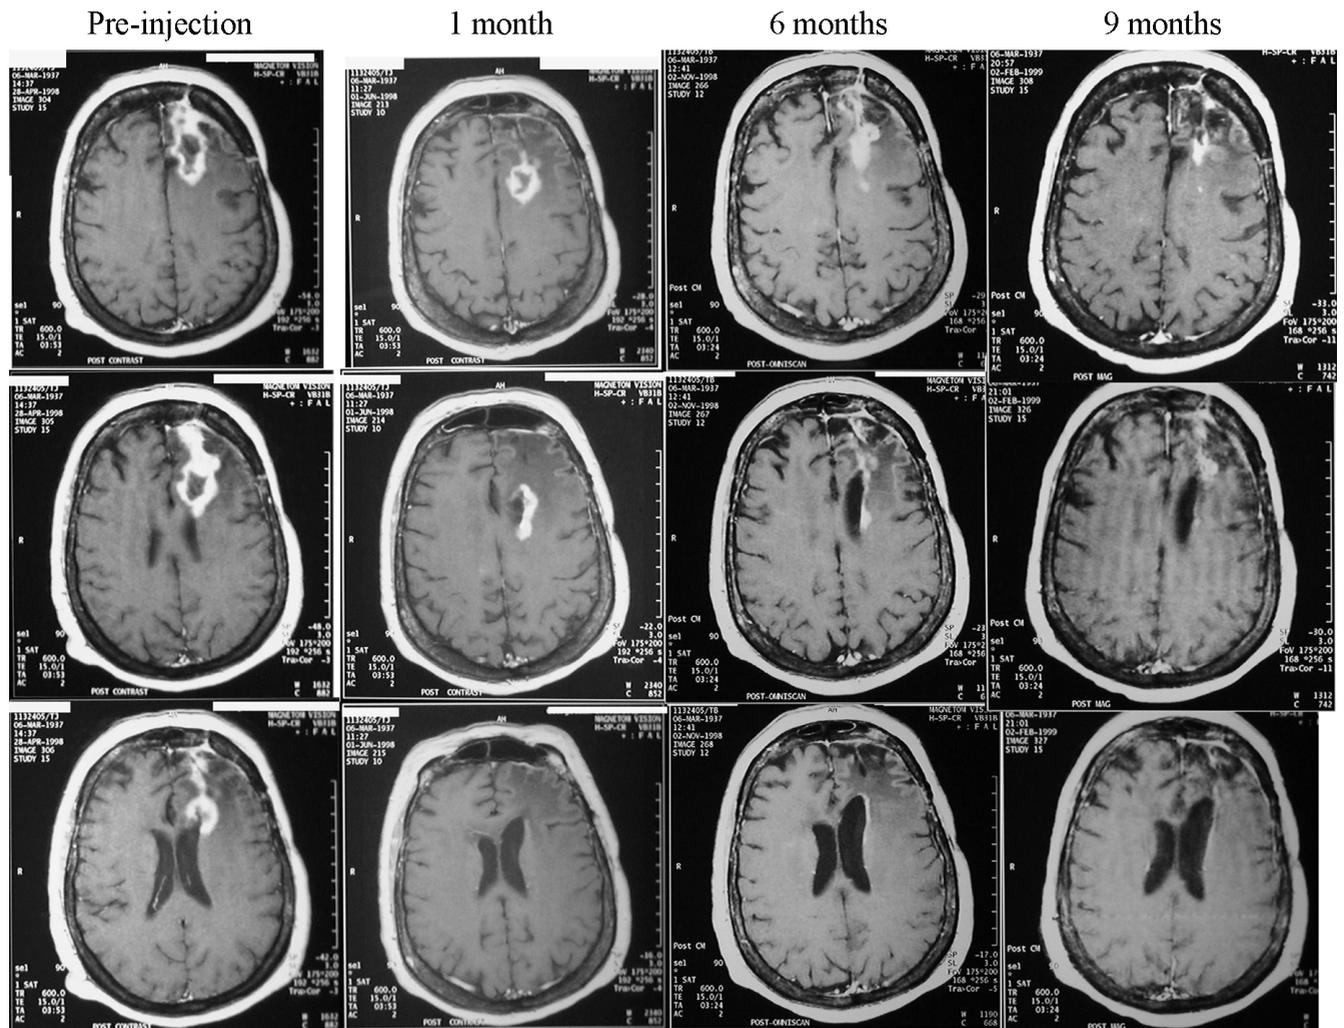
Patient No. 4 MRIs showing regression. Patient No. 4 T1-weighted gadolinium enhanced MRI images. Volumes pre-injected: 21.5 cc; 1 month 23.4 cc; 6 months 21.1 cc; 9 months 17.1 cc.
